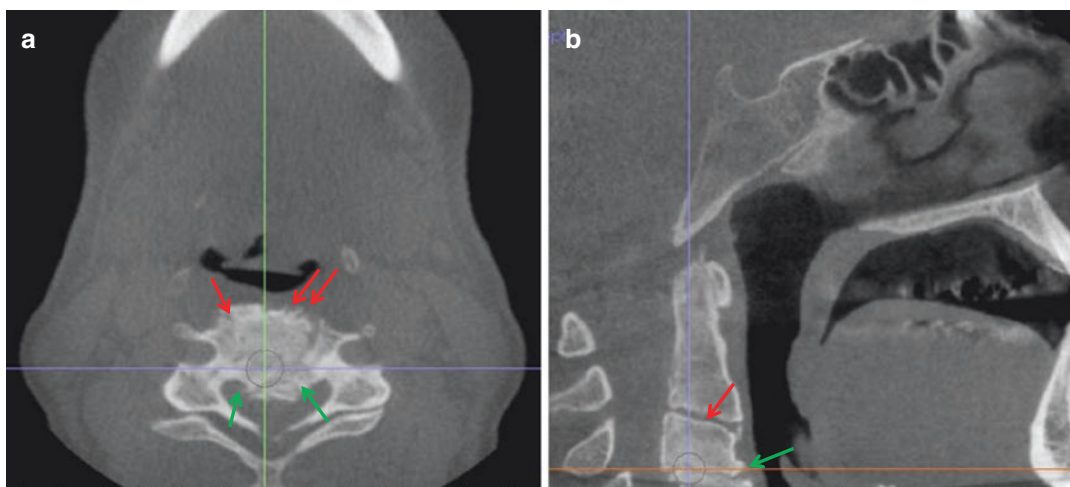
Axial (a), coronal (b), and midsagittal (c) CBCT images of a 16-year-old girl with congenital complete fusion of C2 and C3
